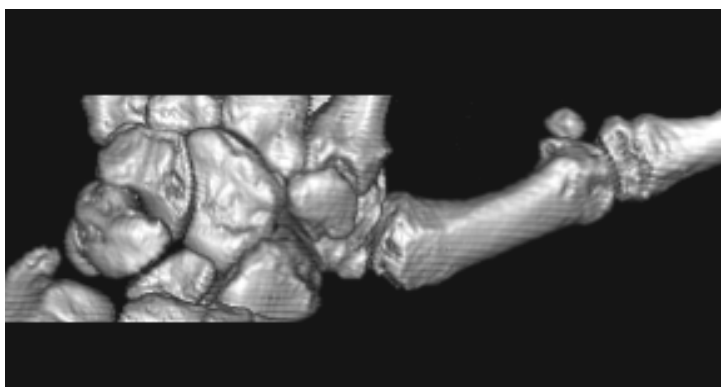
3D CT reconstruction of the metacarpal trapezium joint: rhizarthrosis.
